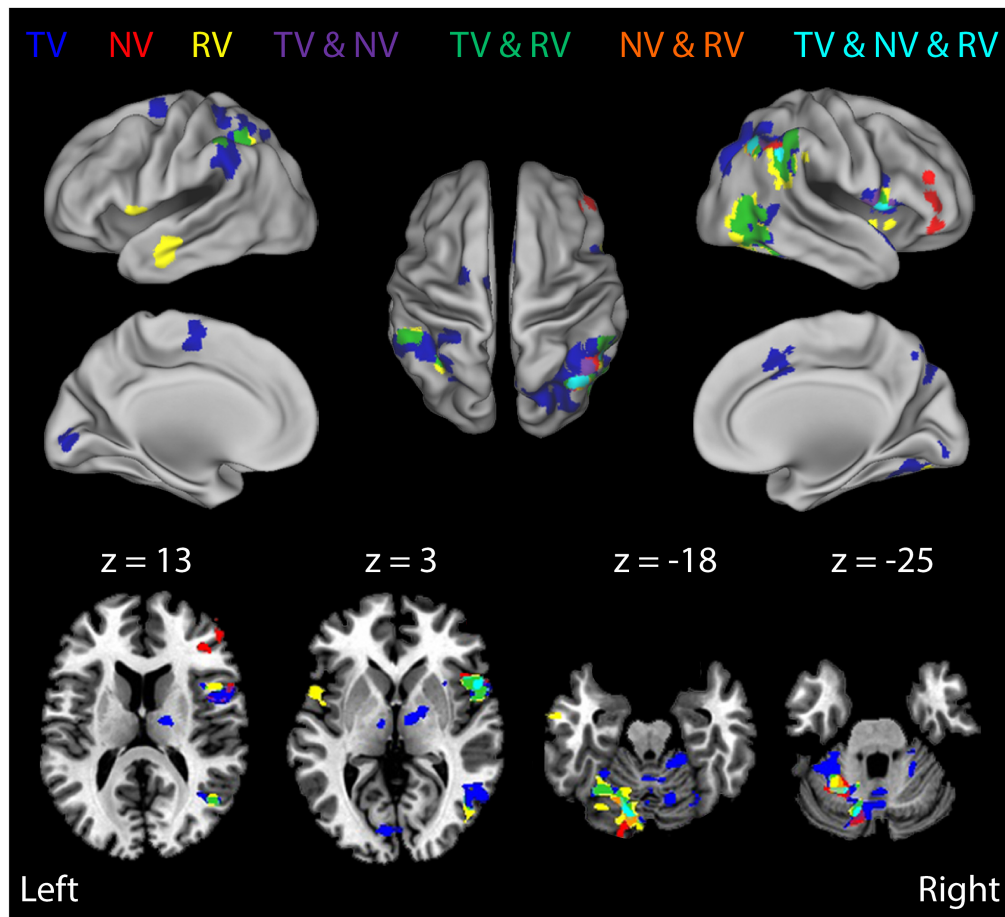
Block-by-block analysis: BOLD signal correlates of ongoing error correction under each of the three visual feedback conditions. Colored regions depict functional activation maps for the study population showing ROIs that exhibited enhanced activation during stabilization against random environmental torques (RT) relative to constant torques (i.e., the RT > CT contrast) for each of the three different feedback conditions (TV: blue; NV: red; RV: yellow). Additional colors indicate regions of overlapping activations (conjunctions) for the three feedback conditions. Neural activities related to error correction are modulated by the presence and fidelity of real-time visual feedback. The results indicate some overlap, but also some differentiation, in regions of activation under the three different feedback conditions.
